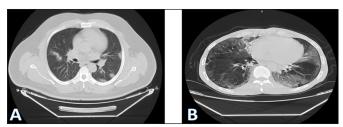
Chest CT image. A. Chest CT image of a 48-years-old RT-PCR negative male patient; irregular subpelural nodular infiltrations B. Chest CT image of a 45-years-old RT-PCR negative male patient; subpleural groundglass infiltrations with crazy paving in lower and middle zones
